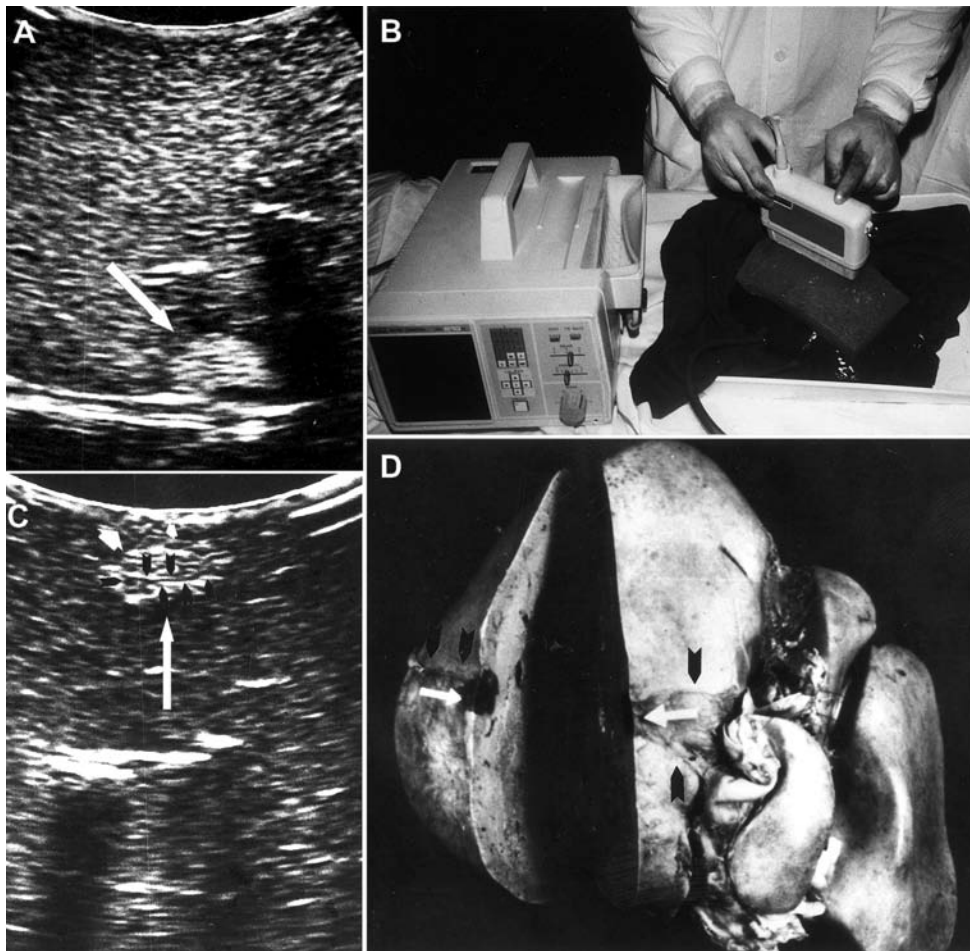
Evidence that ultrasound features of nodular lesions may be successfully detected in post-mortem, human parenchymal organs. A) Subcostal scan obtained during a routine ultrasonographic examination of the liver using a 5 MHz convex probe (Ansaldo AUC 940 real-time scanner). A small hyperechoic nodule (white arrow) is visible in the right lobe adjacent to the visceral surface of the gland. Note fine parallel echoes arranged horizontally and absence of a peripheral hypoechoic halo; B) Sudden death of the patient occurred few months later. The liver, removed from the cadaver, was subjected to ultrasonographic examination, using either an Aloka 210 real-time scanner with a 3.5 MHz linear array-type probe (depicted in the image) or an Ansaldo scanner with 5 MHz convex probe. A layer of *kitekò* material was placed between the transducer and the liver to improve image resolution; C) Parasagittal scan with a 5 MHz convex probe of the isolated liver obtained from the visceral surface of the right lobe. Note a hyperechoic lesion (long white arrow) made up of fine parallel echoes arranged horizontally and forming the wall of internal anechoic, vascular channels (small black arrows). The ultrasonographic features of the lesions are identical to those in A). A hyperechoic bundle (white arrowheads) connects the lesion to the visceral surface of the liver; D) After perfusion fixation of the liver, a parasagittal cut was made on the visceral surface of its right lobe. An hypervascular lesion or hemanagioma was found within the gland parenchyma (white arrows), superficially covered by and in anatomical connection with the gastroduodenal legament (black arrows) (From Toni R, Mosca S, Favero L, Grigioni W, Bolondi L, 1988, unpublished results)
